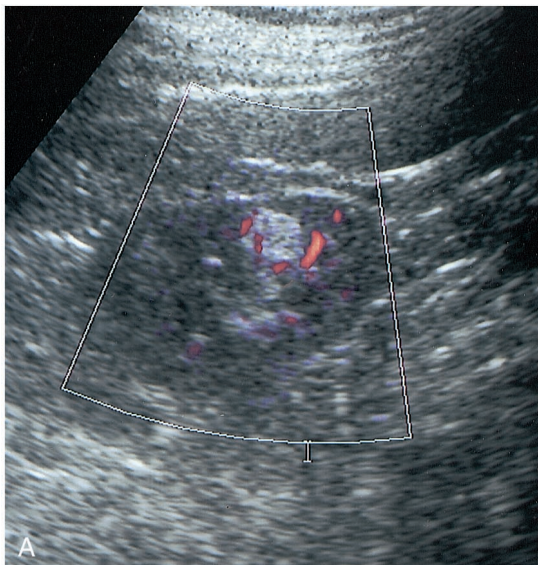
A 42-year-old woman with angiomyolipoma. US power Doppler sagittal scan of the right kidney after Levovist administration shows a 2-cm hyperechoic lesion containing some colored spots (pattern 1).
